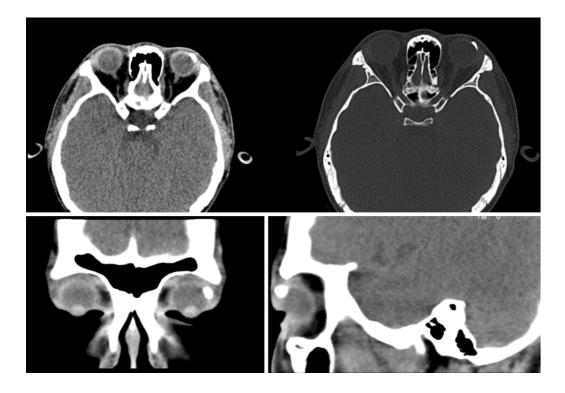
Preoperative computed tomography scan of the mass in the superior temporal quadrant of the left eye (case 1). Lumps of calcification were apparent in the upper left conjunctiva of the left eye.
